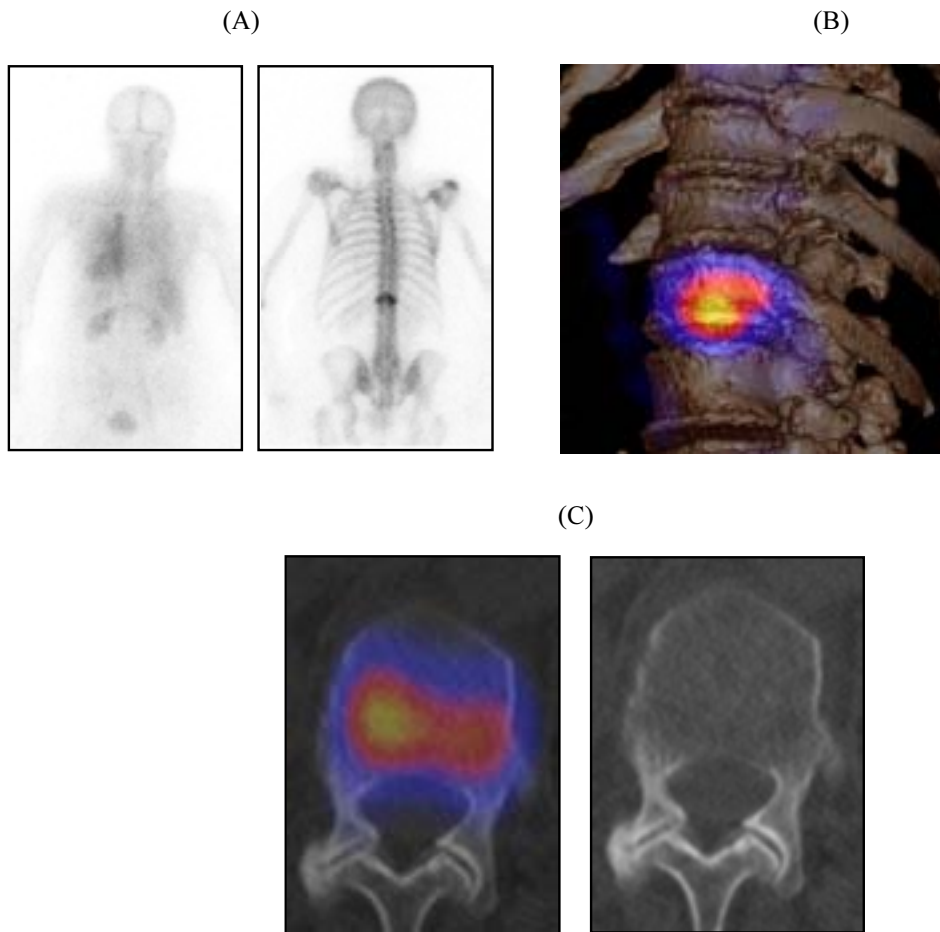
(A) Early (left panel) and late (right panel) posterior planar skeletal scintigrams of a 74 year old patient after recent trauma, showing enhanced uptake of $^{99m}\text{Tc-MDP}$ in a vertebral body of the lower thoracic spine. 3-D-volume rendering of the SPECT/CT fusion (B) shows that the lesion is in the twelfth vertebral body. The inspection of the fused tomograms (C) proves it to be a fracture; moreover, the one-stop shop examination discloses it to be unstable since the posterior corticalis is involved, thus motivating immediate surgery.
